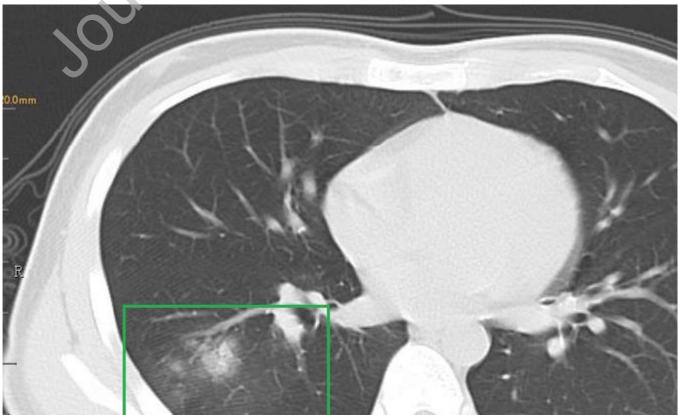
Chest CT imaging of the patient
